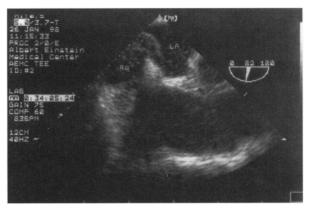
After the injection of microbubbles, transesophageal echocardiogram demonstrates flow of microbubbles from right atrium to left atrium.
